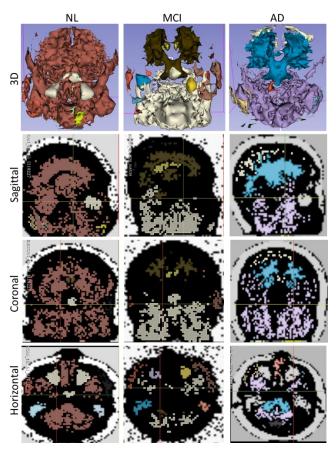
HDBSCAN segmentations of MRI brain scans from NL, MCI and AD patients.
